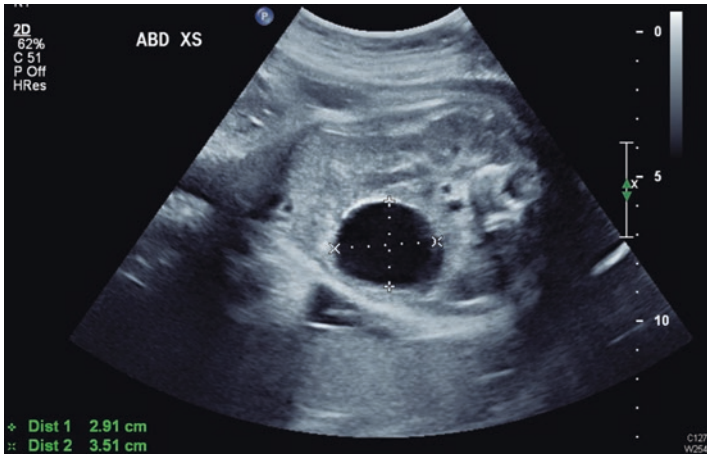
Ultrasound showing a benign simple, right ovarian cyst. Notice the homogeneity and anechoic nature of the cyst. (Courtesy of Robert Weinsheimer, MD, Swedish Medical Center, Seattle, WA).
